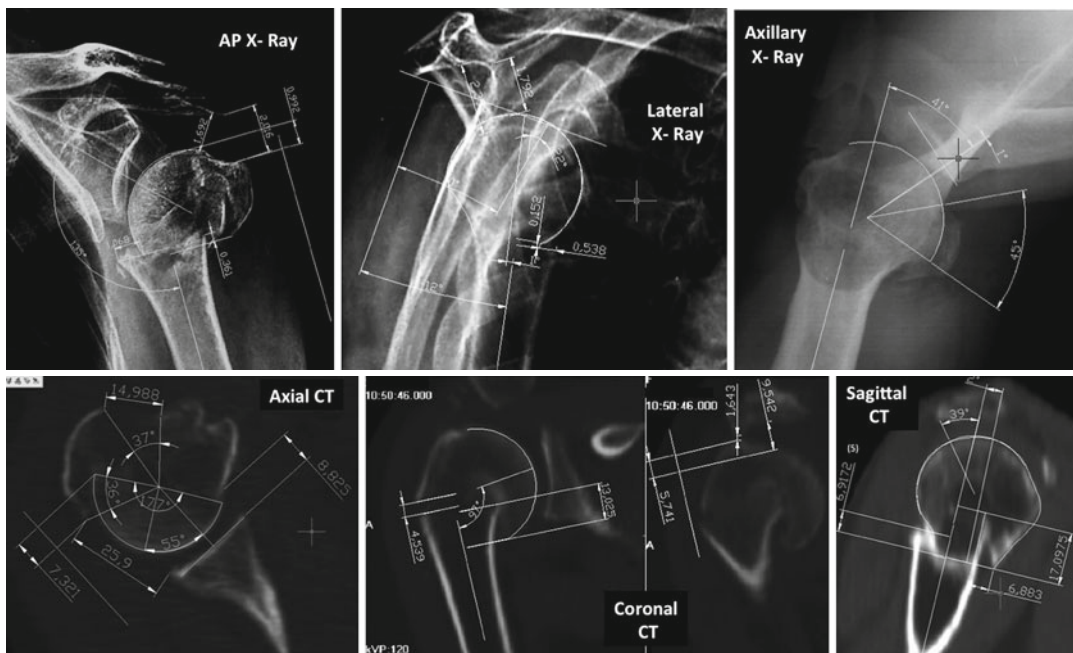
Examples of computed tomography-assisted measurements performed after correction for magnification (Modified with permission and copyright © of the *British Editorial Society of Bone and Joint Surgery* [5])
